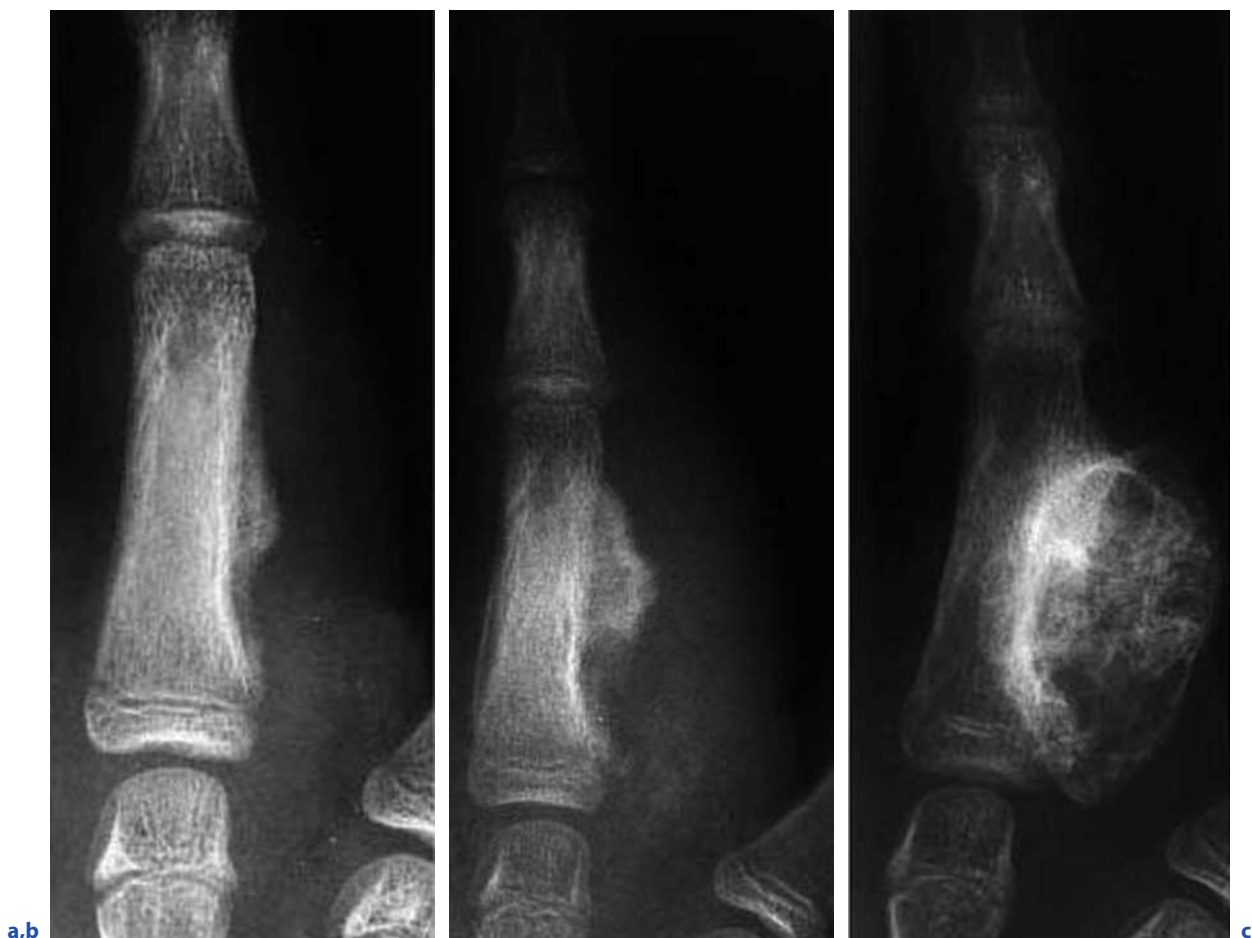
Bizarre parosteal osteochondromatous proliferation (BPOP). a Oblique, b lateral, and c frontal radiographs of the hand show a bulky ossified “osteochondromatous” lesion adherent to the lateral cortex of the fifth metacarpal. The cortex adjacent to the lesion is intact
